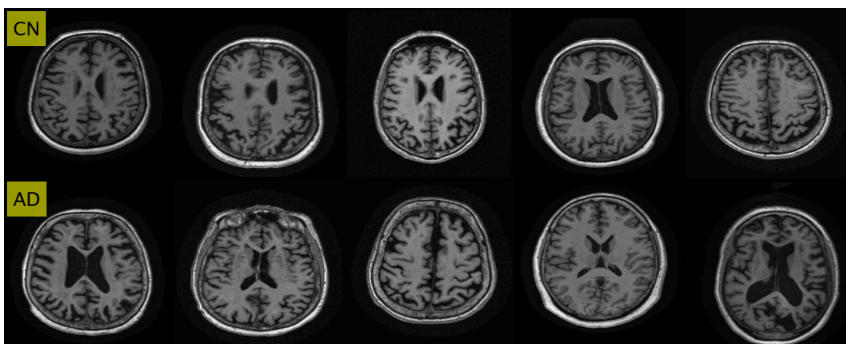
Axial plane: MRI slice Nr. 88 for CN (top) and AD (bottom row)
